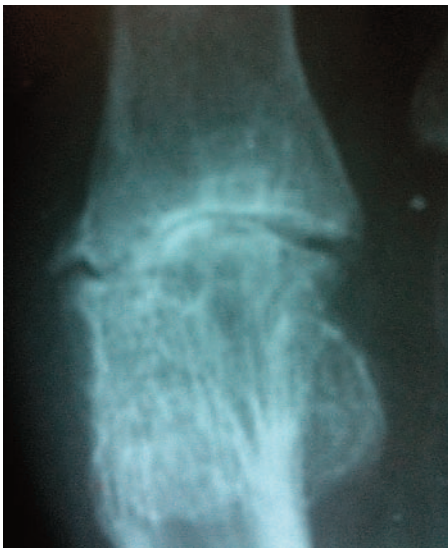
Radiographic appearance of end stage OA with several subchondral cystic changes.
